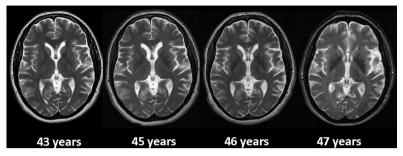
MRI of the proband (III:1): TI-weighted sequence at age 43 years, fluid-attenuated inversion recovery (FLAIR) sequence at age 45, 46 and 47 years. No signal changes are present. Specifically, the basal ganglia are normal and there is no definite focal or general atrophy.
